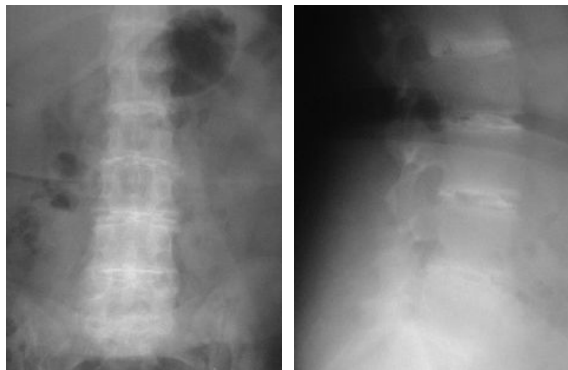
Radiographics of the lumbar spine (A) anteroposterior (B) lateral view
